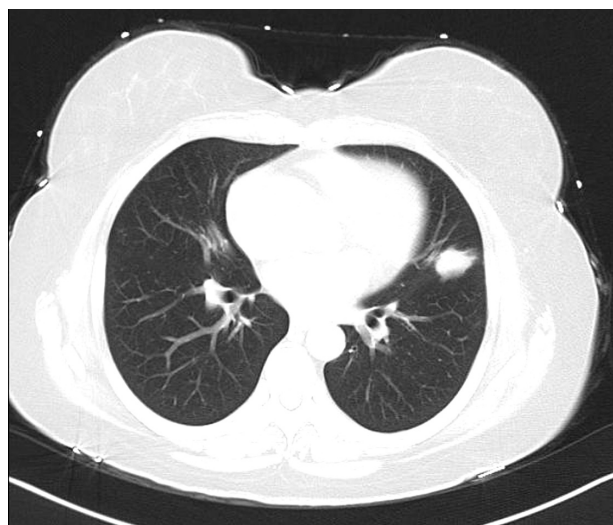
Computed tomography scan showed an irregular abnormal soft tissue mass located in the left upper lobe.
